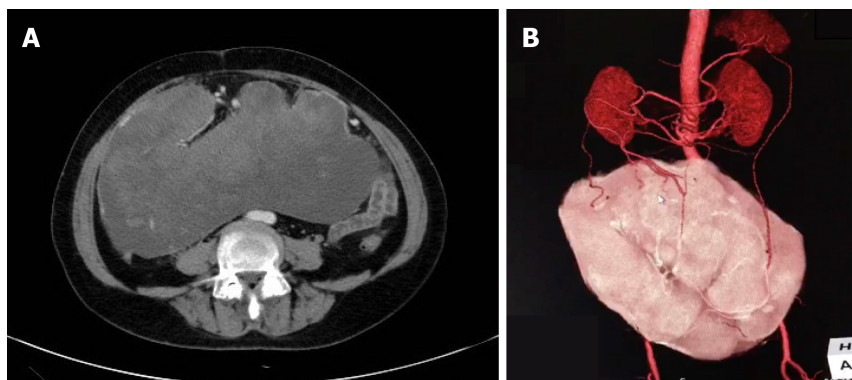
Imaging of the abdominal mass. A: Contrast-enhanced abdominal computed tomography (CT) scan showing a huge mass measuring 25.4 cm × 23.0 cm with mixed density and heterogeneous enhancement (arrow); B: CT 3D reconstruction showing that the feeding arteries were from the splenic artery, right colic artery, and middle colic artery (arrows).
